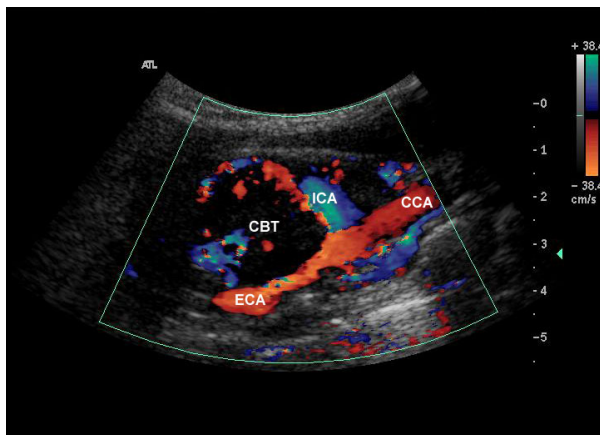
Duplex ultrasound – longitudinal view: carotid body tumour at carotid bifurcation. CCA, common carotid artery; ICA, internal carotid artery; ECA, external carotid artery; CBT, carotid body tumour.
